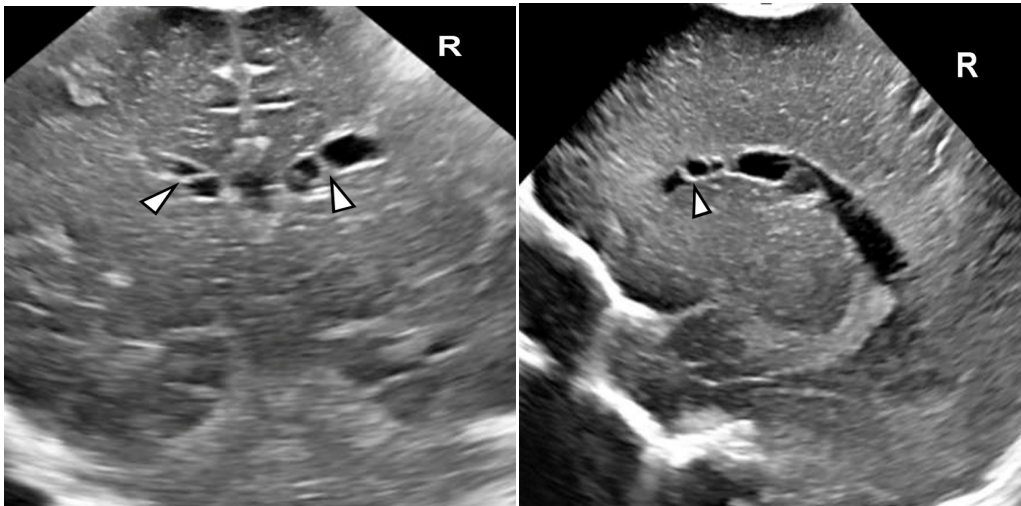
Coronal and saggital views of cranial ultrasound soon on the first day of life showed resolving bilateral intraventricular hemorrhage with intraventricular septations (arrows)
